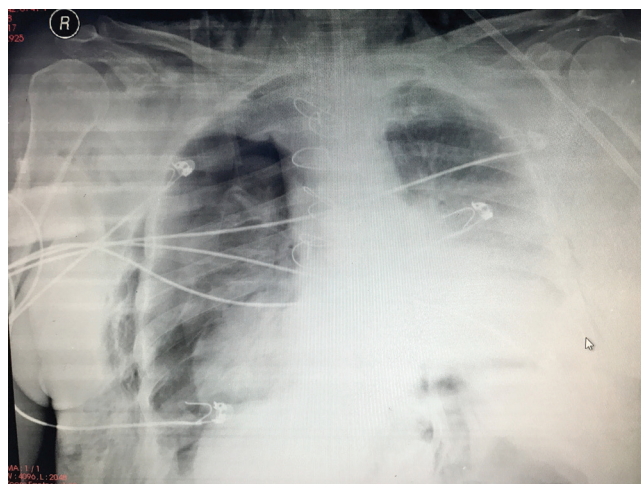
Chest x-ray showing right-sided tension pneumothorax and free air under diaphragm.
